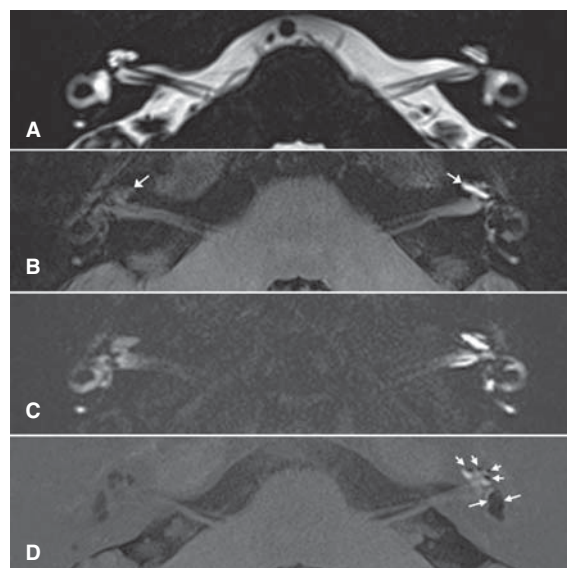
A representative MRI study (patient no. 4 in Table I). (A) Heavily T2-weighted SPACE MRI demonstrates the regular anatomy of the fluid-filled space containing the perilymph and the endolymph. (B) 3D-FLAIR MRI. Gadolinium (Gd) contrast enhancement is obviously stronger in the left ear (IT + IV side) than in the right ear (IV side). The arrows indicate the scala tympani of the basal turn of the cochlea. (C) Heavily T2-weighted 3D-FLAIR MRI (FLAIR constant). The enhancement of the right ear is clearer than that in (B). (D) 3D-real IR MRI. Endolymphatic hydrops (EH) of the left ear (IT + IV side). The short arrows indicate significant EH in the cochlea and the long arrows indicate significant EH in the vestibule. On 3D-real IR MRI, Gd contrast enhancement is not obvious in the right ear (IV side). IT, intratympanic injection; IV, intravenous injection.
